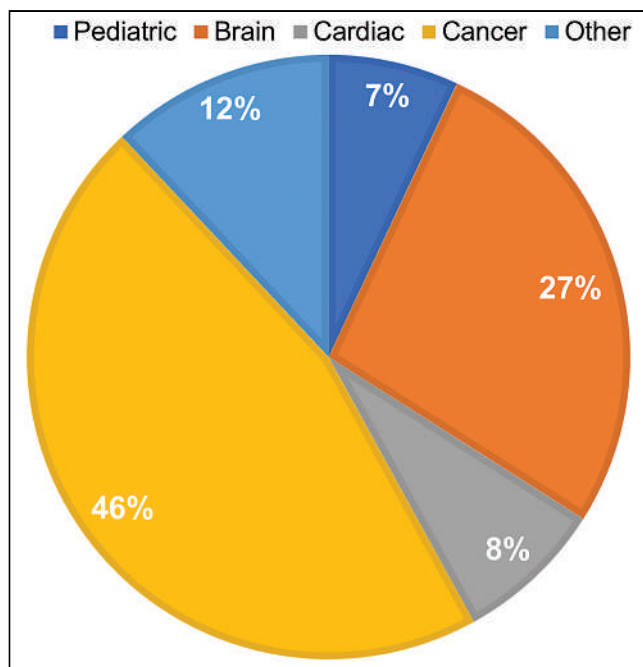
Yearly publication numbers for 2020 from PubMed for PET/MRI show that cancer has greatest engagement, followed by brain, other (unlisted applications), cardiac, and pediatric.
